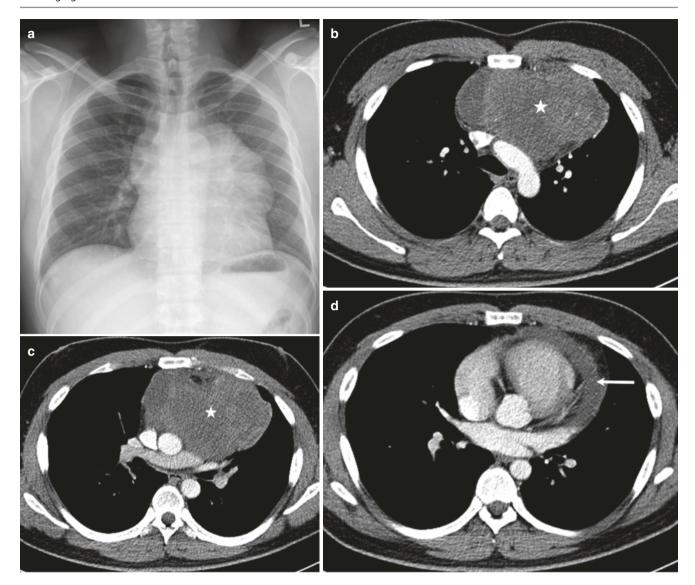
28-year-old man with yolk sac tumor in the anterior mediastinum. (a) Frontal radiograph shows a large anterior mediastinal mass, silhouetting the right and left heart borders but not obscuring the descending aorta. "Hilum overlay" sign is present.
